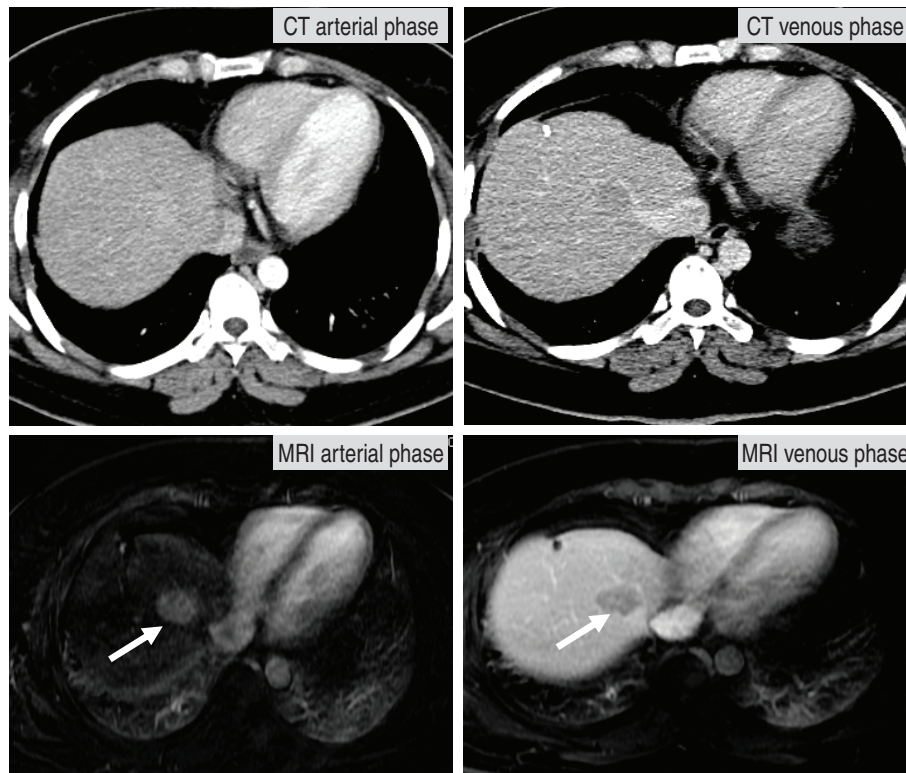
A 39-year-old female, S/P left hepatectomy for HCC, presenting with rising AFP. CT was first performed and missed the lesion. MRI was later able to detect a liver nodule, showing arterial enhancement and venous washout, typical for a new focus of HCC.
